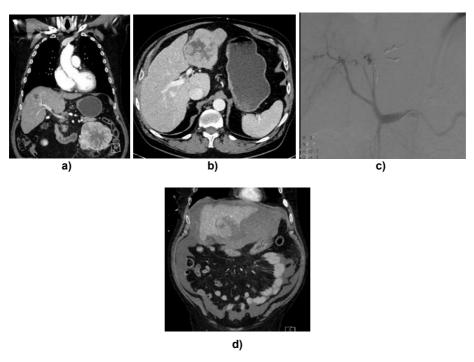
Incidentally found synchronous liver metastasis of RCC which ended up being treated by angioembolisation due to acute bleeding. a) Preoperative CT image: 16 cm tumour in left kidney. b) Preoperative CT image: Large 6.5 cm metastasis in liver. c) Before consultation of urologist, the patient arrived at the ER due to stomach pain. Active, life-threatening, bleeding from liver metastasis was noted in the CT. d) Emergency angioembolisation was made and stopped the bleeding. Liver resection and nephrectomy were planned as the patient had Heng risk status of good/intermediate risk. CT images were provided by the HUS urology clinic patient archives.
